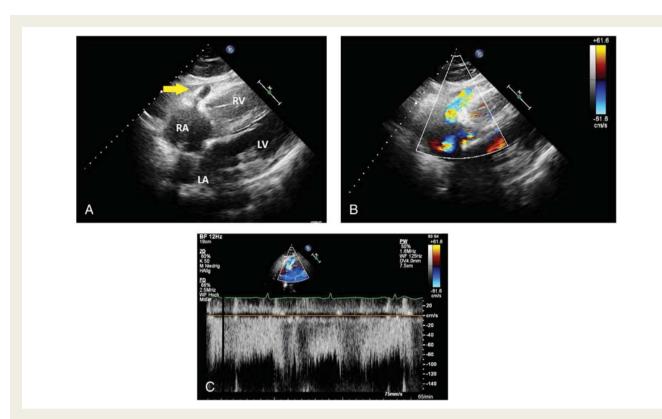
Figure I (A) Subcostal two-dimensional view demonstrated the fistula (arrow) draining into the right atrium. (B) Colour-Doppler of the same image shows the blood flow in the fistula. (C) A continuous Doppler curve of the fistula. RA, right atrium; RV, right ventricle; LA, left atrium; LV, left ventricle.
